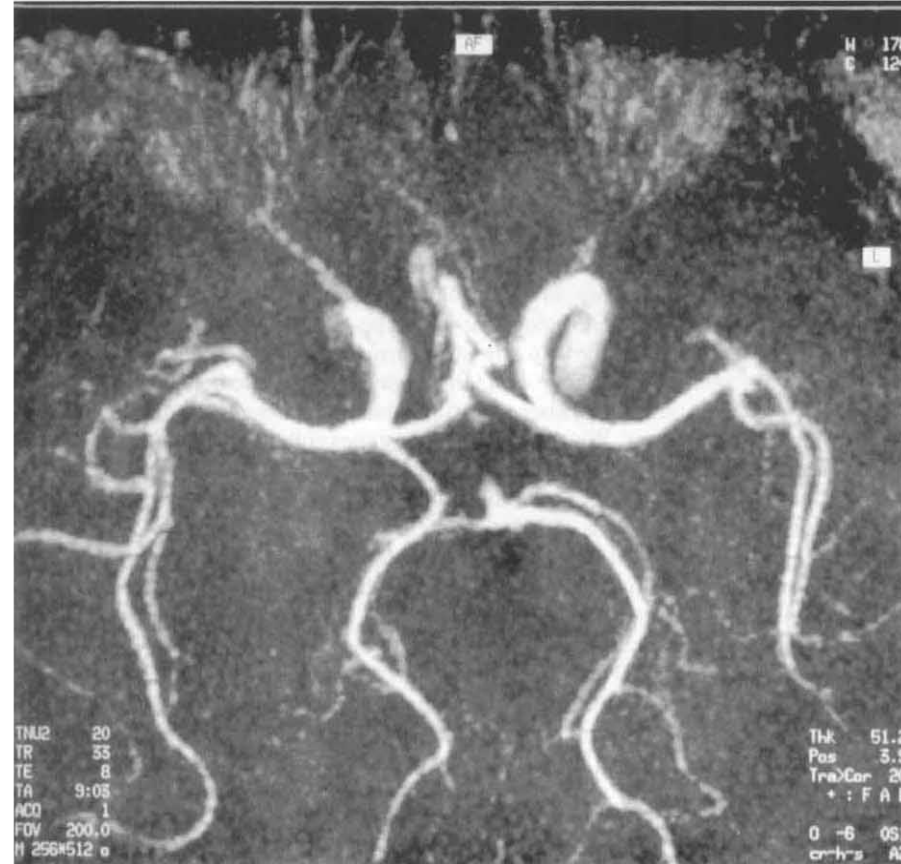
A. Cerebral magnetic resonance imaging five years after cerebral infarction. B. Cerebral magnetic resonance angiogram.
